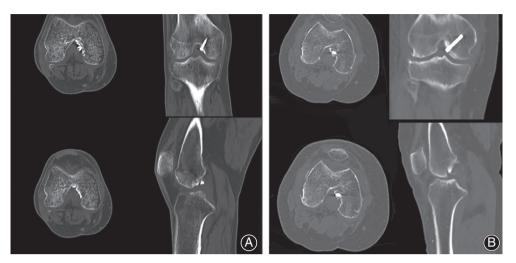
The CT of the two female patients 3 months after surgery showed the fragments avulsed healed at the intercondylar fossa. The screws were fixed at the same location of the footprint. The patient could perform weight-bearing walking and the drawer test of the knee was negative. (A) The 63-year-old woman. (B) The 68-yearold woman.
